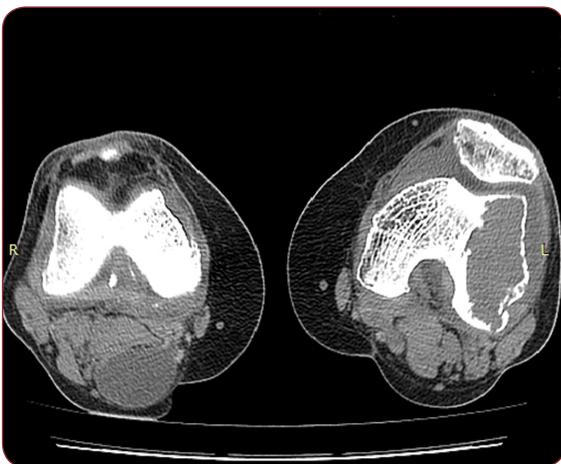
CT image of femoral condyle lesion
